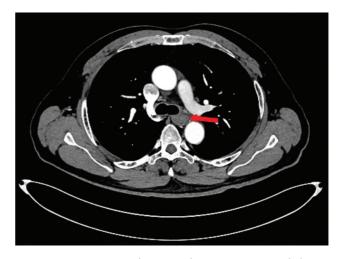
Intensive computed tomography examination revealed a space-occupying lesion in the esophageal cavity (The red arrow in the figure).
